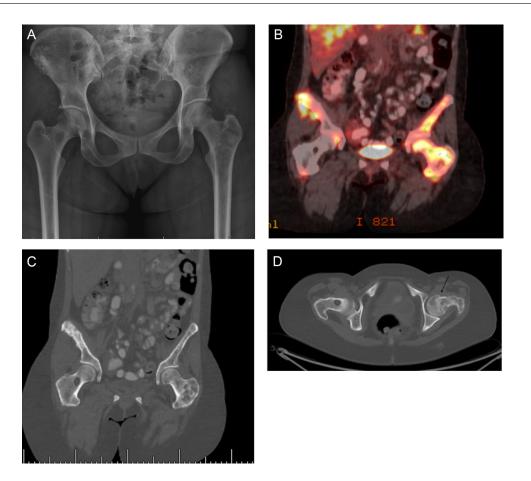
Initial images. (A) Pelvis AP radiograph obtained in 2018 due to left hip pain, no fracture is noted on the exam. Subsequent PET-CT scan obtained in 2019 for disease surveillance, intense uptake with SUV of 13.34 noted in the proximal left femur (B) along mixed lytic-sclerotic lesion in the proximal left femur (C) and femoral neck fracture (arrow) better visualized on the axial view (D).
